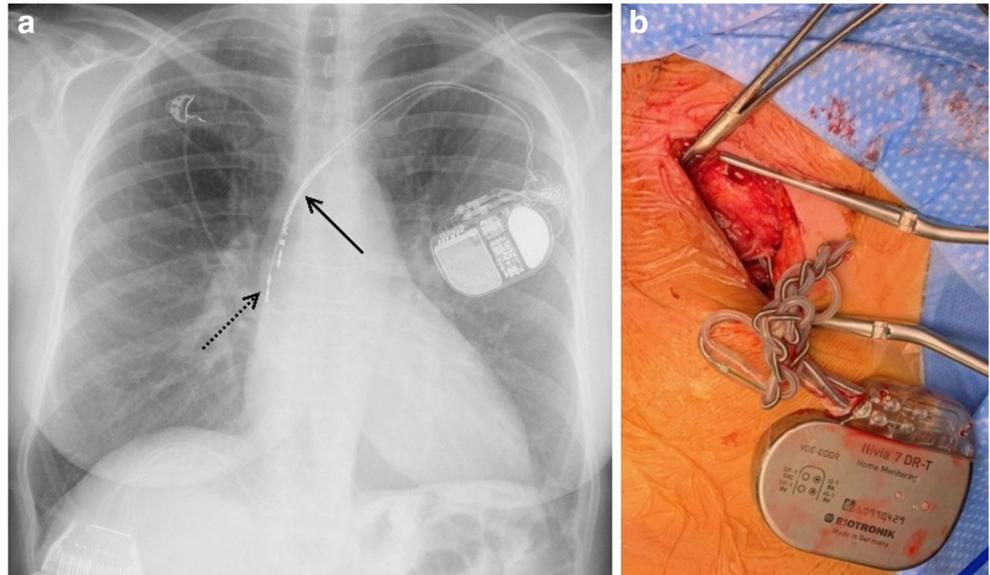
a X-ray showing the dislodgment of both leads (solid arrow, ventricular lead; dotted arrow, atrial lead). b Intraoperative situs during ICD revision
